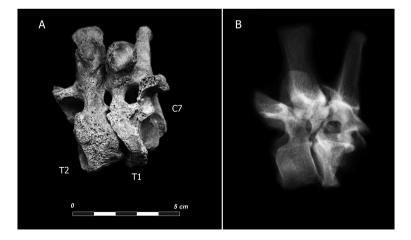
Lateral view (right) of three vertebral bodies C7, T1 and T2 (case 1). C7 and T1 are affected by lytic lesions. A: Collapse of C7 and fusion to T1 provoking kyphosis. The body of T2 presents post deposit modifications. B: Saggital X-ray view of C7-T2 showing collapse of C7, loss in body height of T1, irregular condensation of the trabecular bone, fusion of vertebral bodies of C7 and T1 as well as the apophyseal joints in the three vertebrae.
